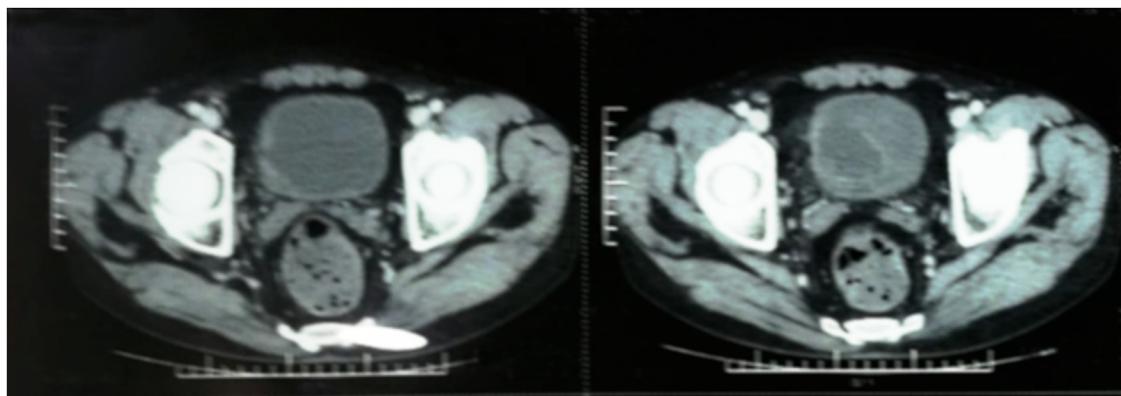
Thoraco-abdomino-pelvic computed tomography scan cross-sectional view showing a bladder mass.
